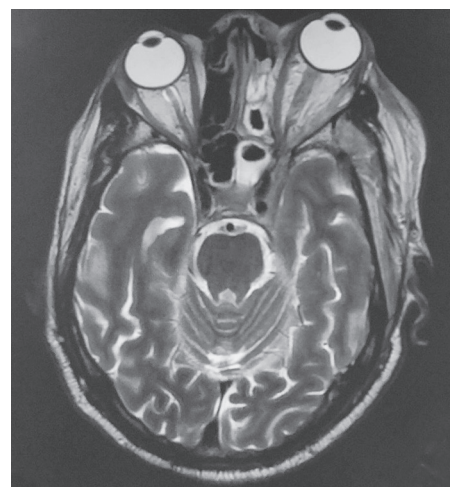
MRI postcontrast T1W axial left sphenoidal and ethmoidal sinusitis with left cavernous sinus thrombosis and proptosis
